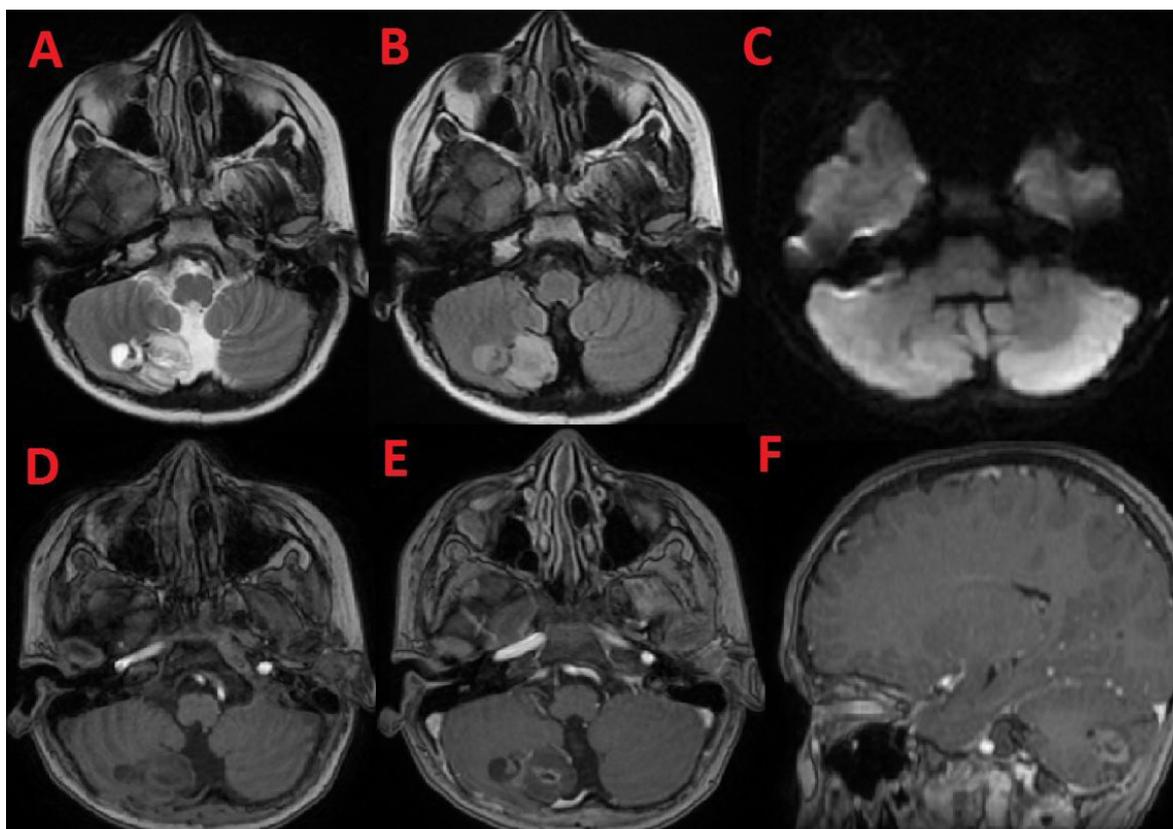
Head MRI. A: Axial T2; B: Axial T2 FLAIR; C: Diffusion weighted imaging; D: Axial T1; E: Axial T1+Contrast; F: Sagittal T1+Contrast
